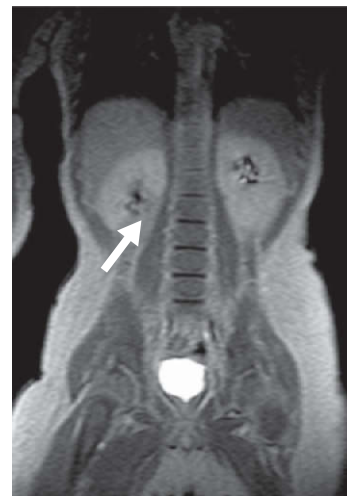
Magnetic resonance imaging of the abdomen. T1-weighted images showed a focal, relatively hypointense area at the lower pole of the right kidney, with poor enhancement. A focal cortical retraction adjacent to this lesion was also noted.
